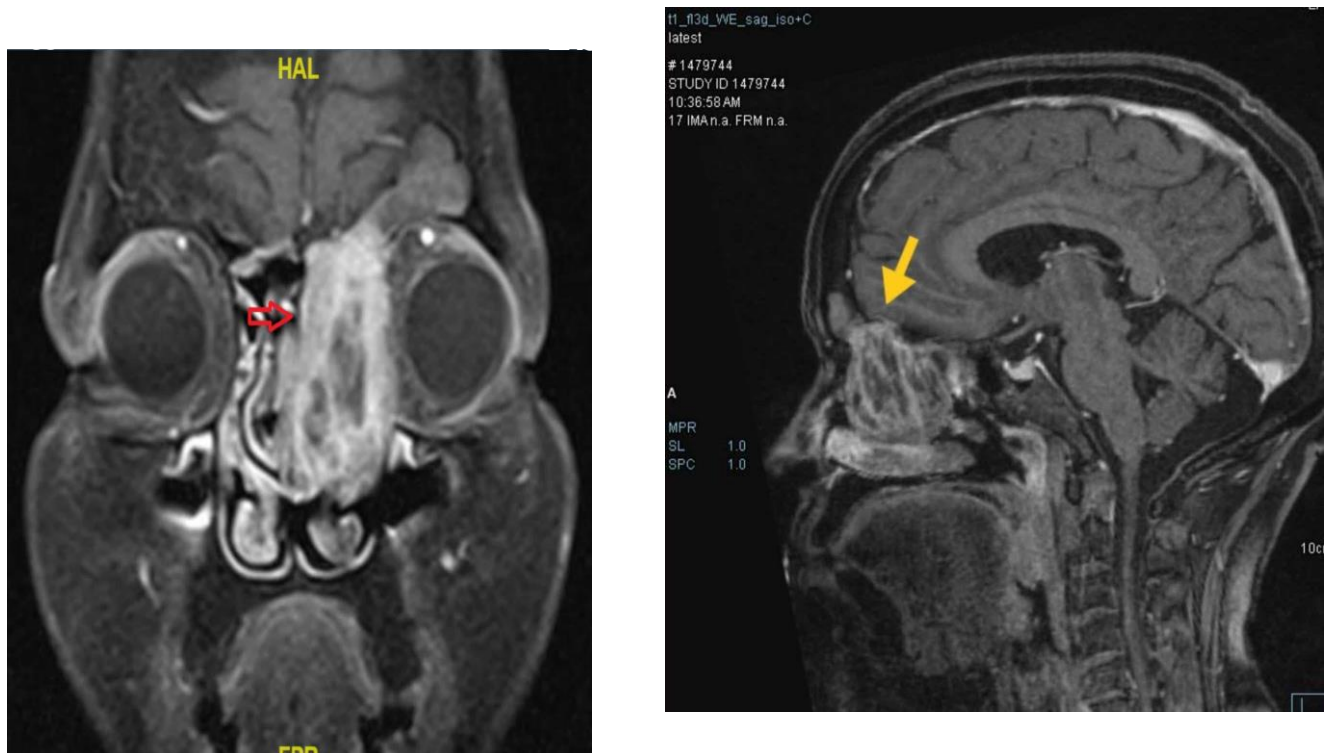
CT and MRI T1W (coronal view) imaging showed erosion of the anterior skull base
